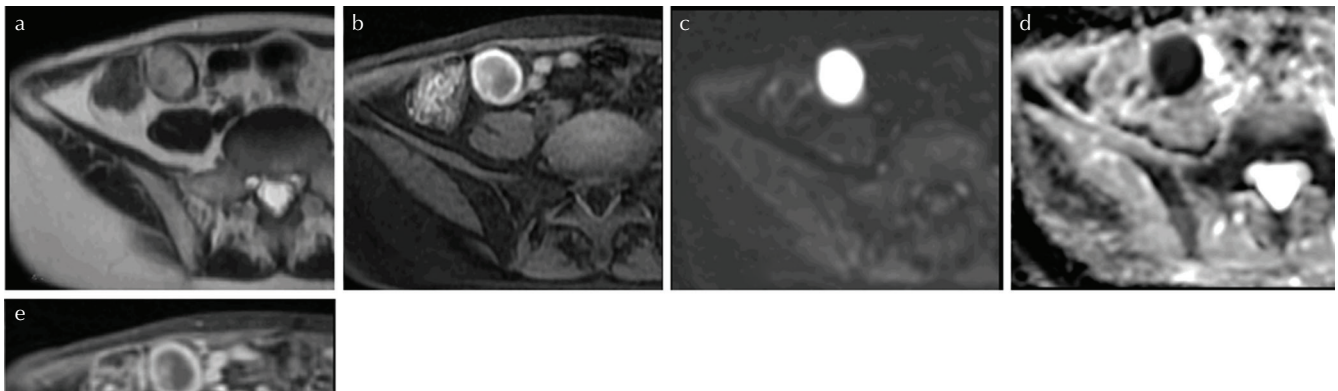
(a) Axial T₂-weighted images (T₂WI) reveals a mass approximately 2 cm in diameter in the right lower abdomen showing heterogeneous high signal intensity. (b) The mass shows low signal intensity with peripheral high intensity on axial fat-suppressed T₁-weighted images (T₁WI). (c and d) On diffusion weighted image (DWI), the mass has high signal intensity with a low apparent diffusion coefficient (ADC) map ($0.486 \times 10^{-3} \text{ mm}^2/\text{s}$). (e) The mass shows no enhancement on fat-suppressed T₁WI after injection of gadolinium.
